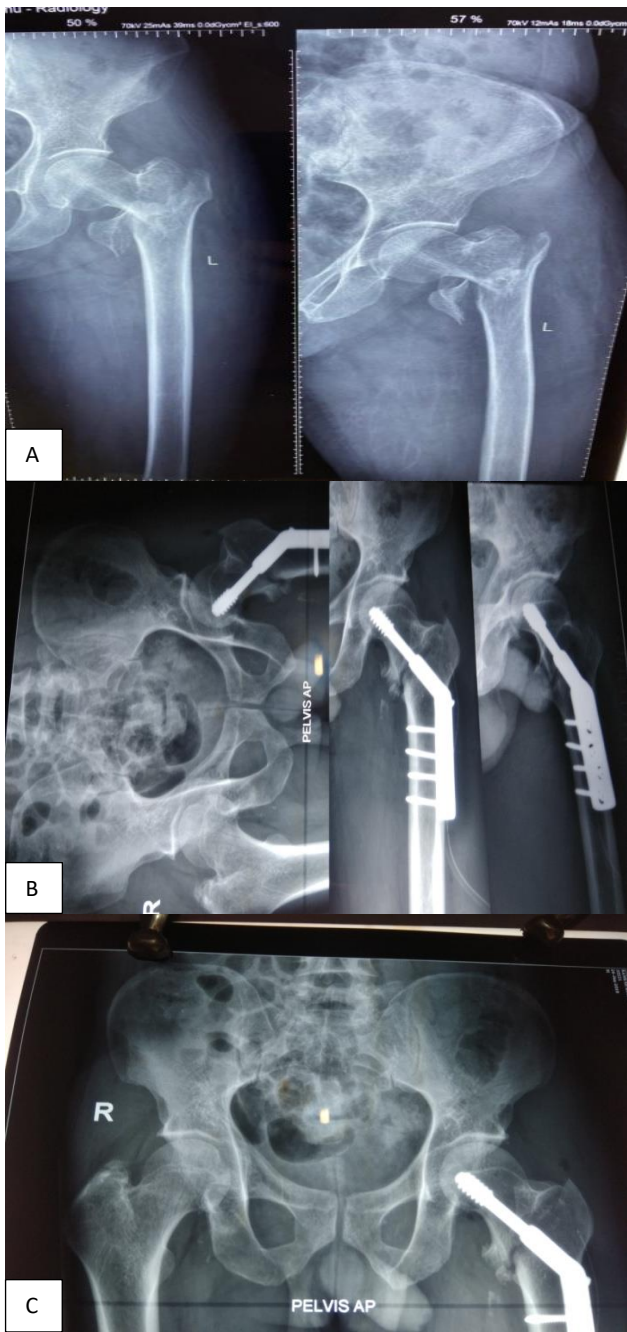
(A, B and C) Pre-operative X-ray and post-operative X-rays of DHS.
